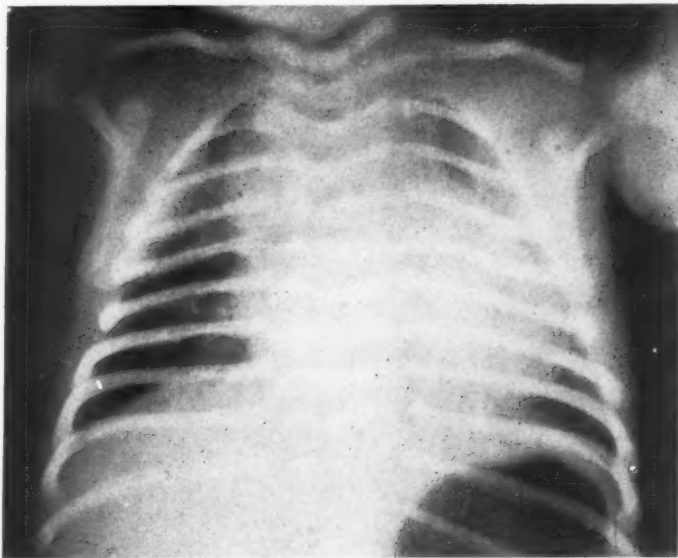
Roentgenogram of chest in Case 1. Note the large and globular shaped heart, especially prominent in the left side of the chest. Described in text.
